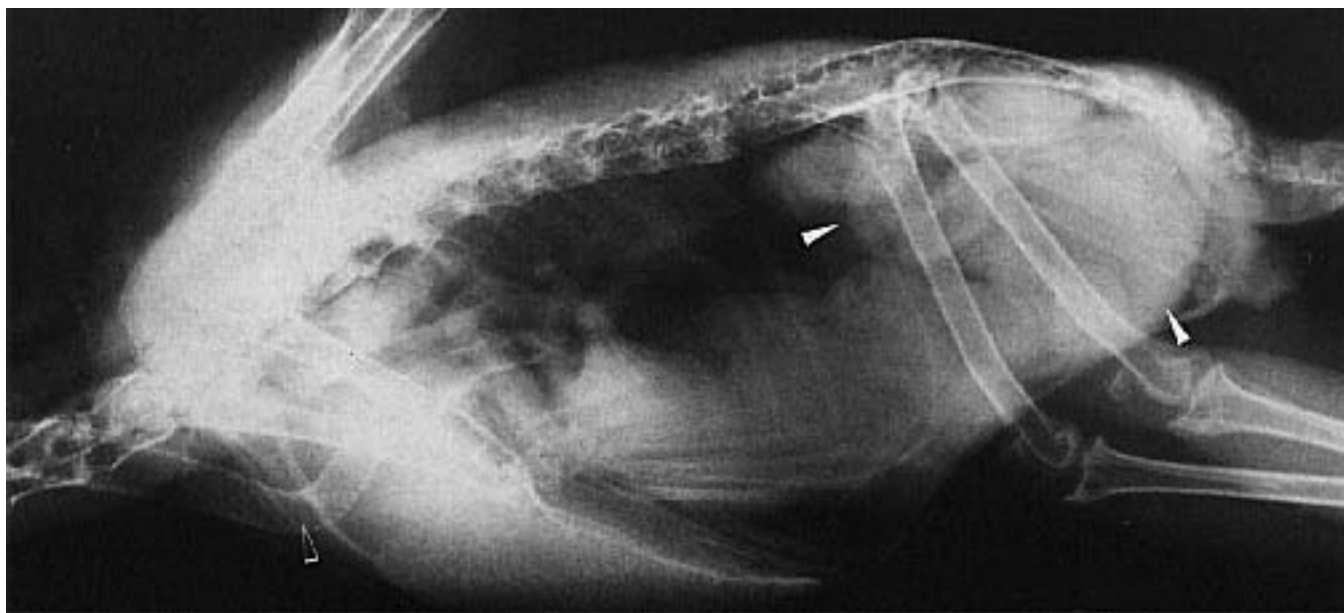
A three-year-old Toco Toucan was presented with a progressive posterior paresis of four months' duration. Clinical pathology findings were unremarkable. Radiographs indicated enlarged kidneys. Necropsy findings included renal tubular necrosis and multifocal nonsuppurative neuritis. Note the normal ventral deviation of the trachea (open arrow) in the thoracic inlet. The normal bowel loops (arrows) of toucans appear distended when compared to those of similarly sized Psittaciformes.
